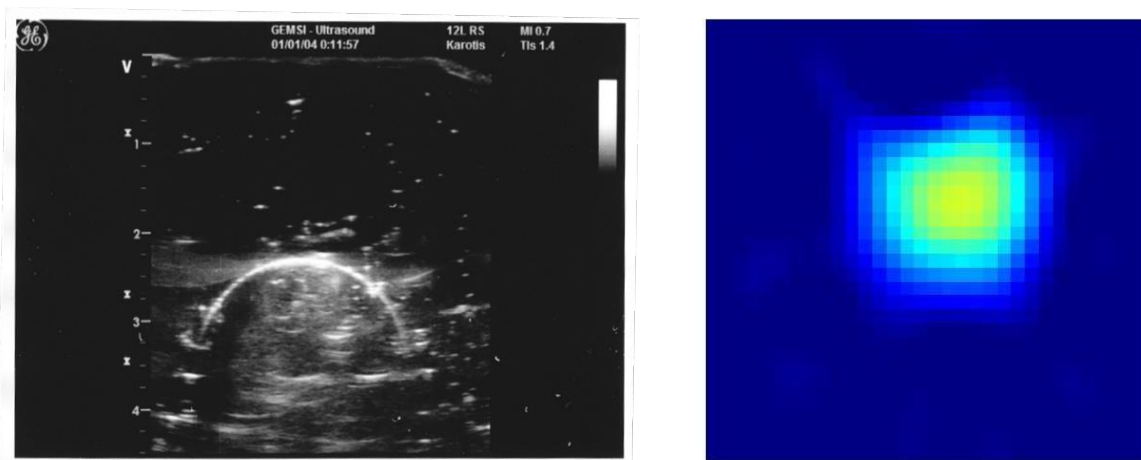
Sonogram (left) of fully inflated cuff and functional tidal EIT image (right).
